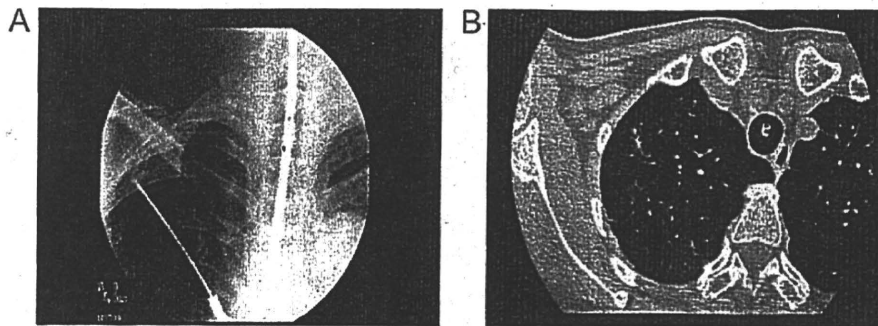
Transbronchoscopic biopsy (A) under X-ray fluorography guided and (B) under computed tomography (CT) guided.
